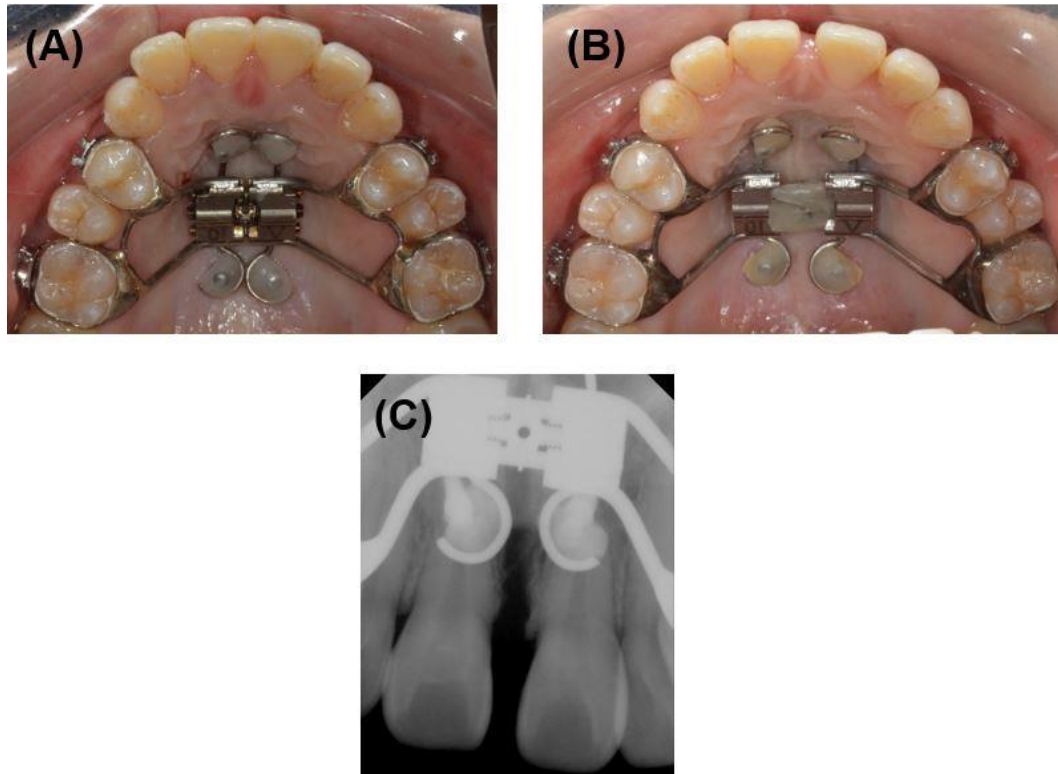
Nonsurgical maxillary expansion using MARPE appliance is shown. (A) after setting appliance, before expansion; (B) just after nonsurgical expansion; (C) periapical radiograph of upper incisors after expansion.
